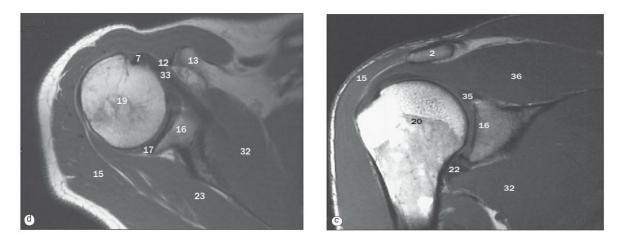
Sample of shoulder joints under magnetic resonance imaging [adapted from (Weir et al., 2010)]
